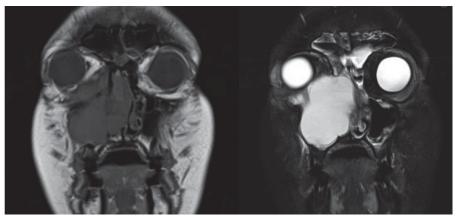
MRI with and without intravenous contrast of a right maxillary sinus mucocele that has eroded the right orbital floor
